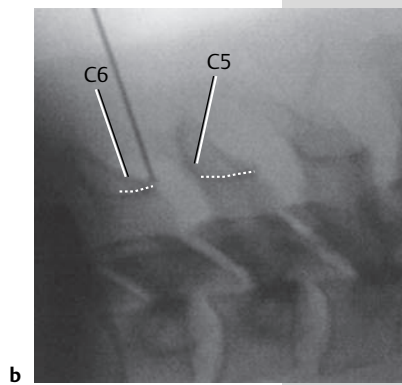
b The position of the needle during insertion, demonstrated first posterior to the lamina at C5/6 on a skeletal model (a) and during image conversion monitoring using a lateral radiograph (b).
